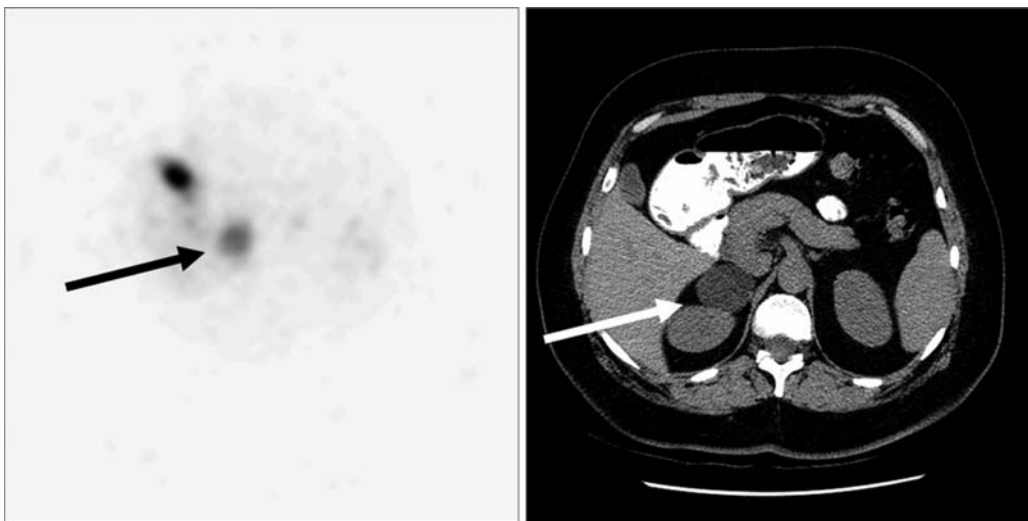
A denotes I-131 and NP-59 Static images and B represents the corresponding CT image in an adenoma of a patient with Cushing's syndrome.
